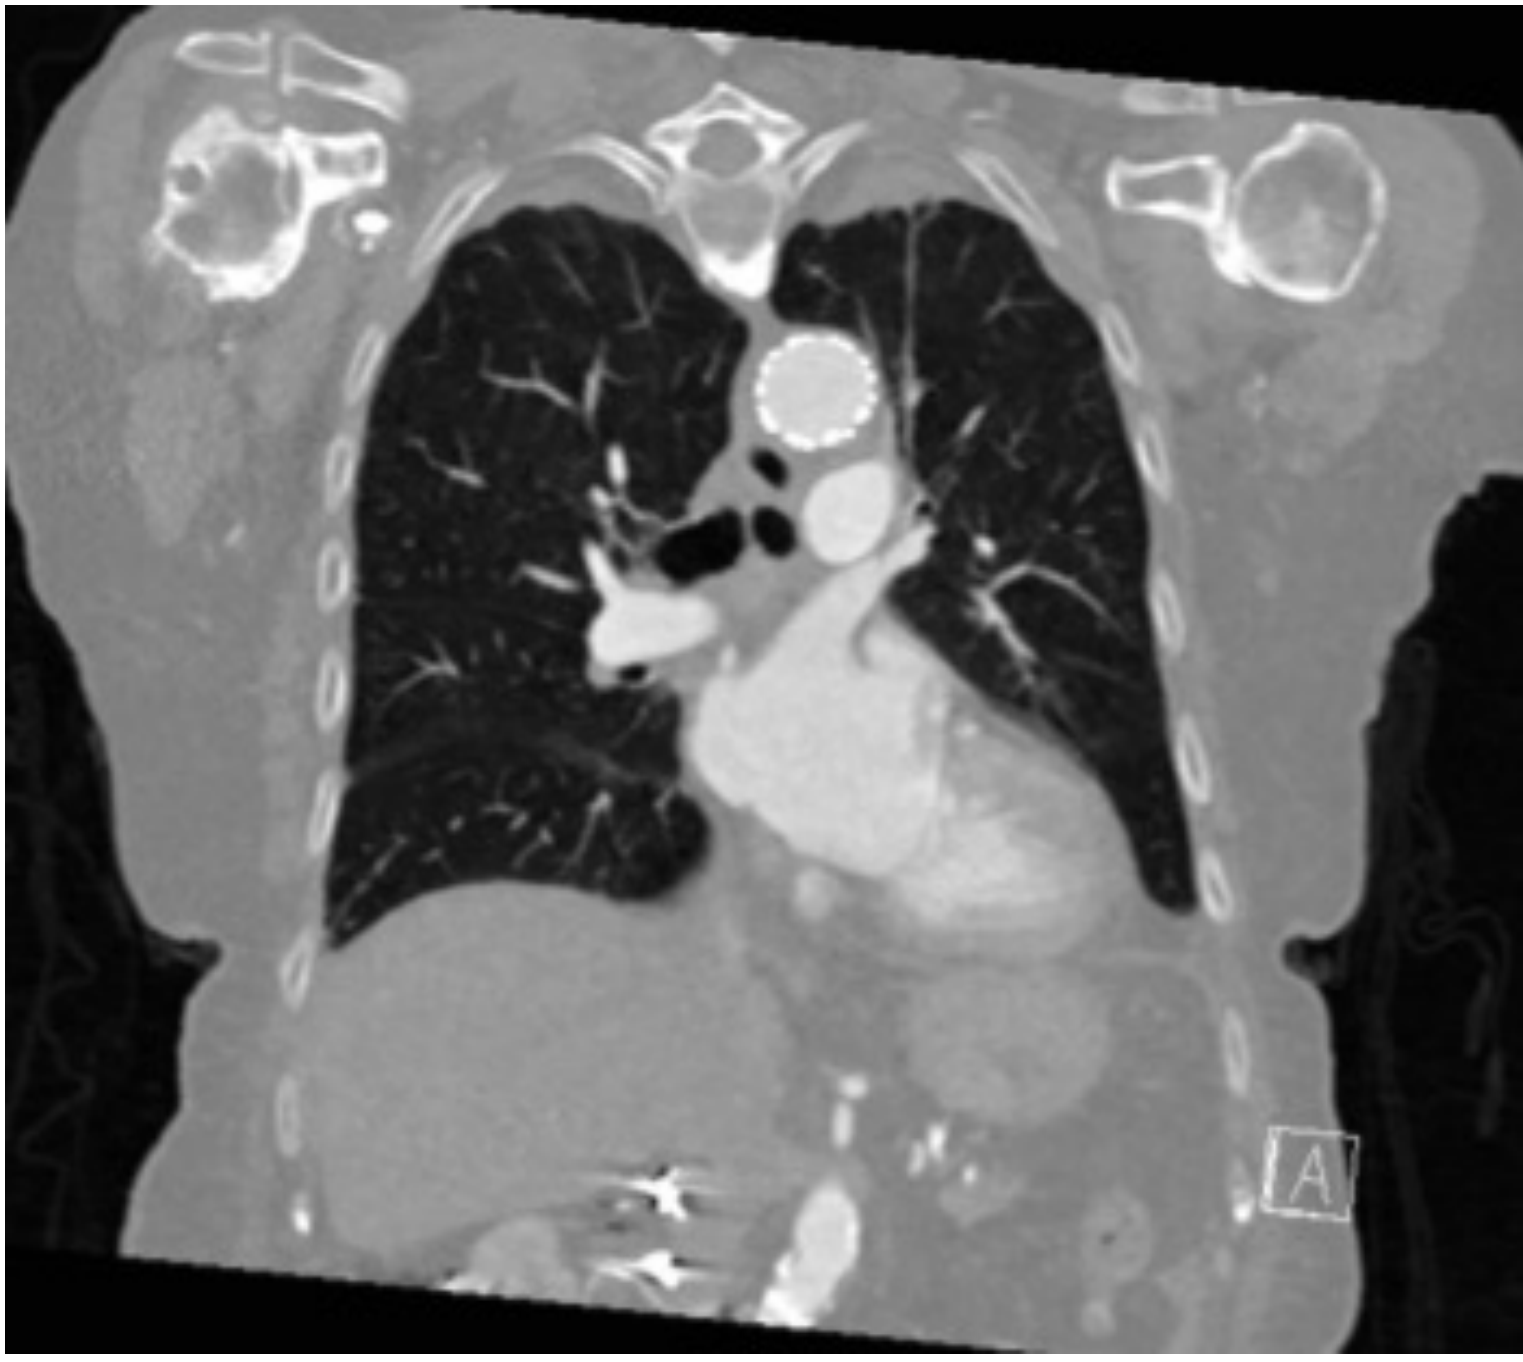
Computed tomography showing endovascular repair of an aortic aneurysm causing dysphagia aortica.
